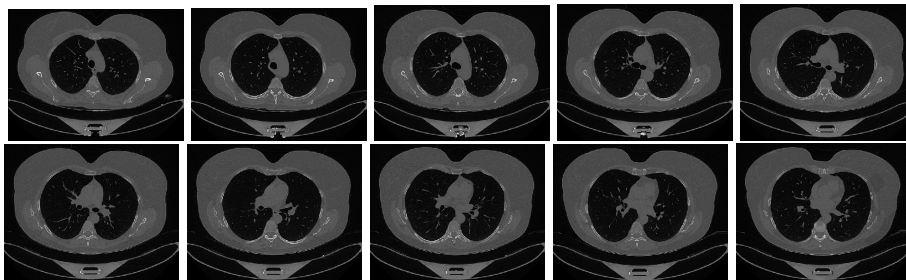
Slices from non COVID-19 cluster center 9 in COV19-CT-DB
